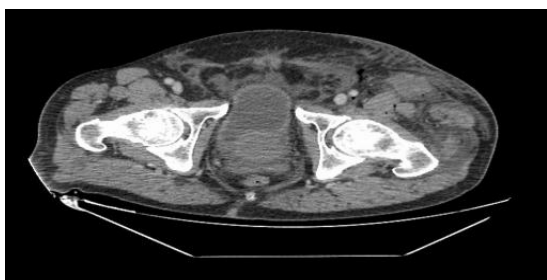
CT images - cross section with free gas: Hips and lower pelvis.
